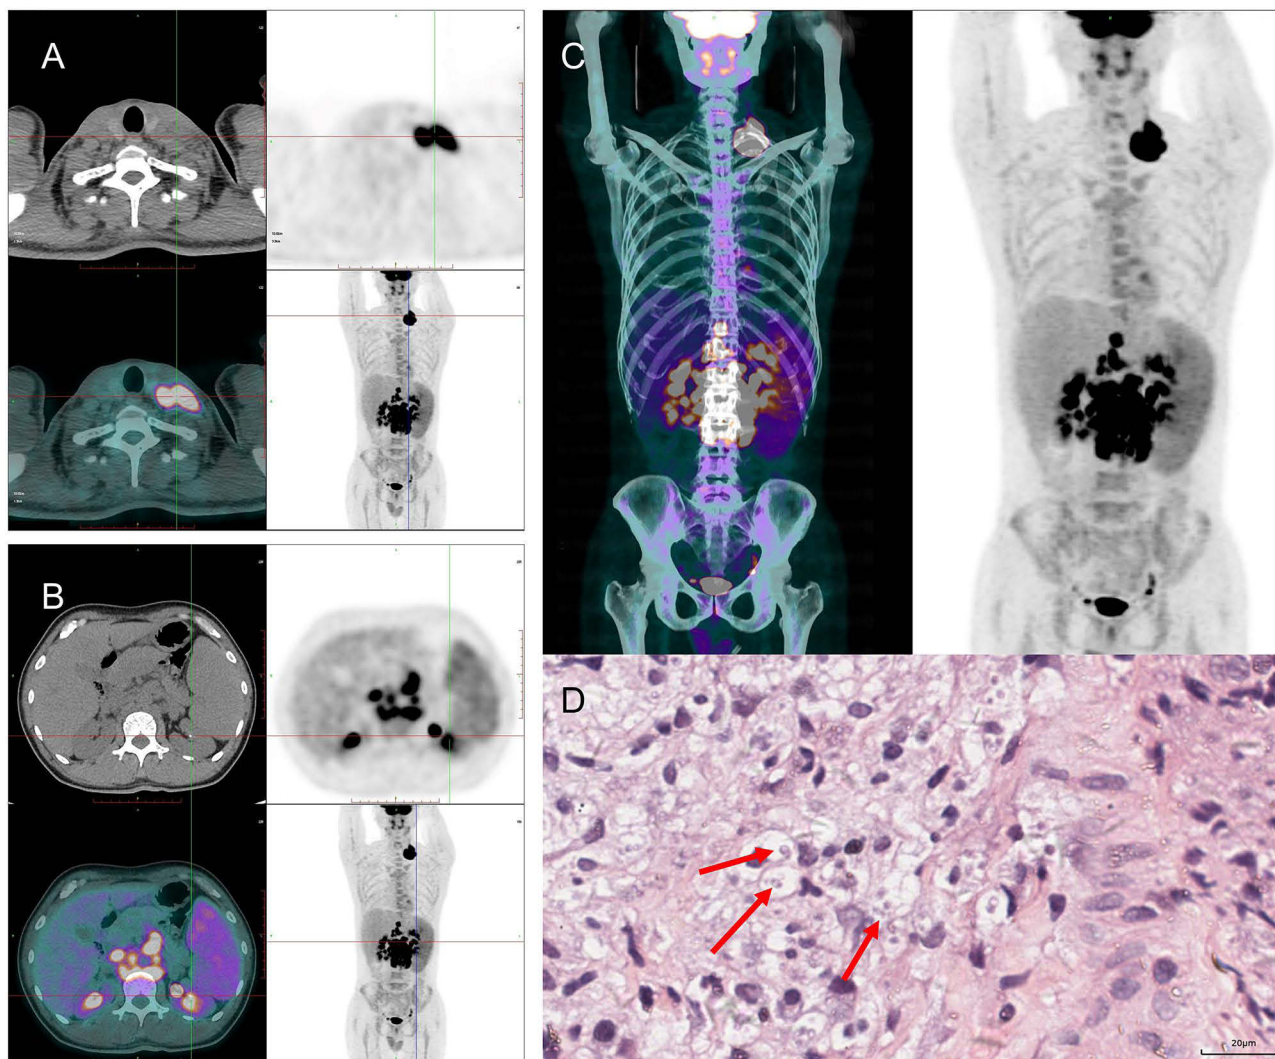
(A) In the PET/CT images of Case 6, multiple enlarged lymph nodes with abnormally increased FDG metabolism were observed in the left supraclavicular region. (B) In the PET/CT images of Case 6, multiple enlarged lymph nodes with abnormally increased FDG metabolism were observed in the retroperitoneal region. (C) In the whole-body PET/CT images of Case 6 (from the skull to the upper thighs), multiple enlarged lymph nodes with abnormally increased FDG metabolism were observed. (D) Fine-needle Aspiration Biopsy of the Left Cervical Lymph Node of case 6: The three red arrows indicate *Talaromyces marneffei*.
